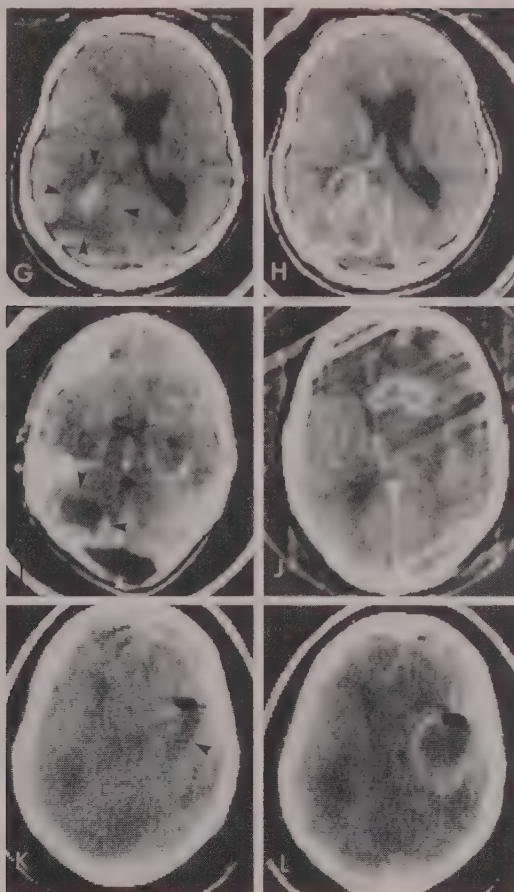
Continued.* G and H, Hemorrhage into an astrocytoma after open biopsy and cyst decompression (not CT-guided). G, NCT reveals compression of the left atrium and occipital horn by a lucent left parieto-occipital mass (arrowheads) with central hemorrhage. H, CECT reveals a ring blush far larger than the hemorrhage itself. The discrepancy in size between the hemorrhage and the ring blush suggest that this is not a simple hematoma (Cf D. above). I, Operative bed. 46 year old woman 2 weeks after resection of left cerebellar ependymoma. CECT reveals a ring blush of irregular thickness (black arrowheads), lesser displacement of the fourth ventricle than seen on previous CT scans (white arrow), and a pseudomeningocele (white arrowhead). J, Radiation Necrosis. 66 year old woman with carcinoma of the right maxillary sinus, status post 6700 to 7100 rads to the right frontal lobe. CECT reveals a ring blush in the right frontal lobe with surrounding fronto-ganglionic lucency and marked midline shift. K and L, Gas abscess. 47 year old woman. Case courtesy James Naidich, M.D., and Roger Hyman, M.D., Manhasset, New York. K, NCT reveals marked ventricular compression and a focal collection of air (white arrow) superior to a lucent mass (arrowhead). L, CECT demonstrates a ring blush circumscribing the air and the mass. This air moved freely in the abscess cavity with changing patient position (compare with Figure 25, a multilocular abscess).
